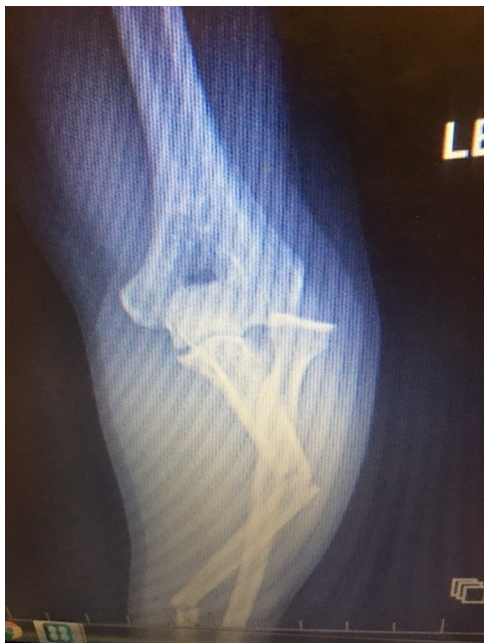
Anteroposterior radiograph of elbow, segmental Monteggia fracture-dislocation.
